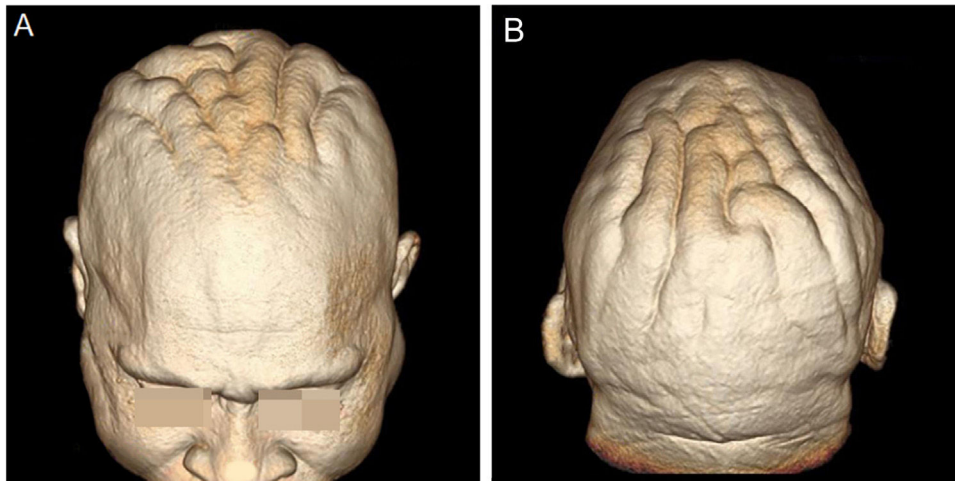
(A and B), Three-dimensional (3D) reconstruction of the cerebriform skin from the magnetic resonance imaging of the cephalic segment.
